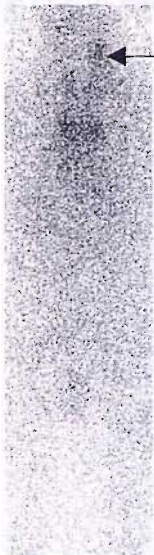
A) Gamma camera image taken on day 4 post dosimetric dose administered to patient RD without prior induction rituximab or pre-dose. Activity localised to the left neck (arrow) correlates with a 5 cm mass of lymphoma demonstrated on the CT (arrow). B) Gamma camera image taken 4 days after 1st dose of RIT having completed induction rituximab and been given pre-dose. The activity in the left neck is no longer present correlating with almost complete clinical resolution of the mass.
